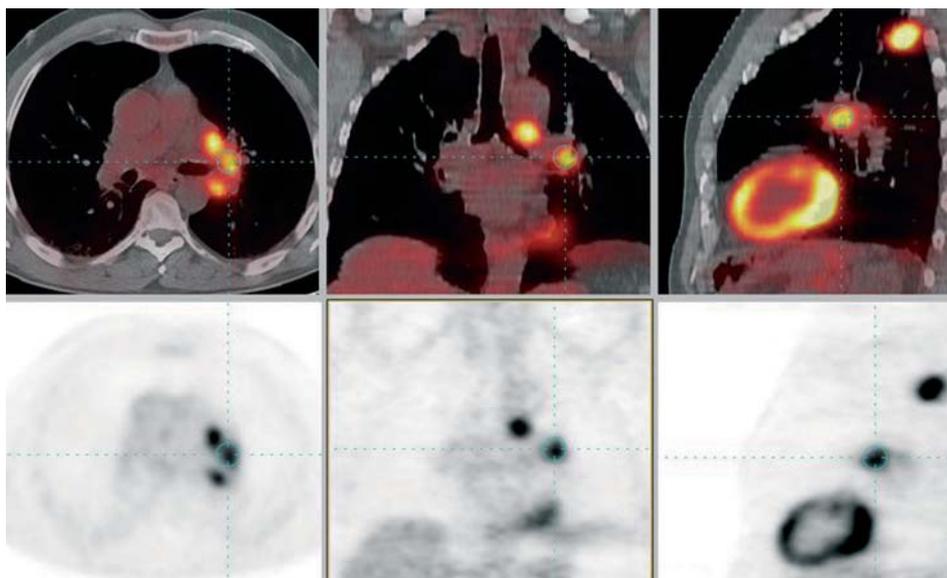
Mediastinal staging of non-small cell lung cancer. Positron emission tomography–computed tomography: malignant lesion in the upper left lobe with enlarged nodes in the aortopulmonary window and the left pulmonary hilum.
